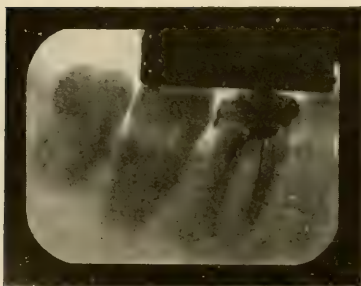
Wires in lower first molar. X-rays passed through tooth diagonally; arrows No. 1 and No. 2, Fig. 436.
